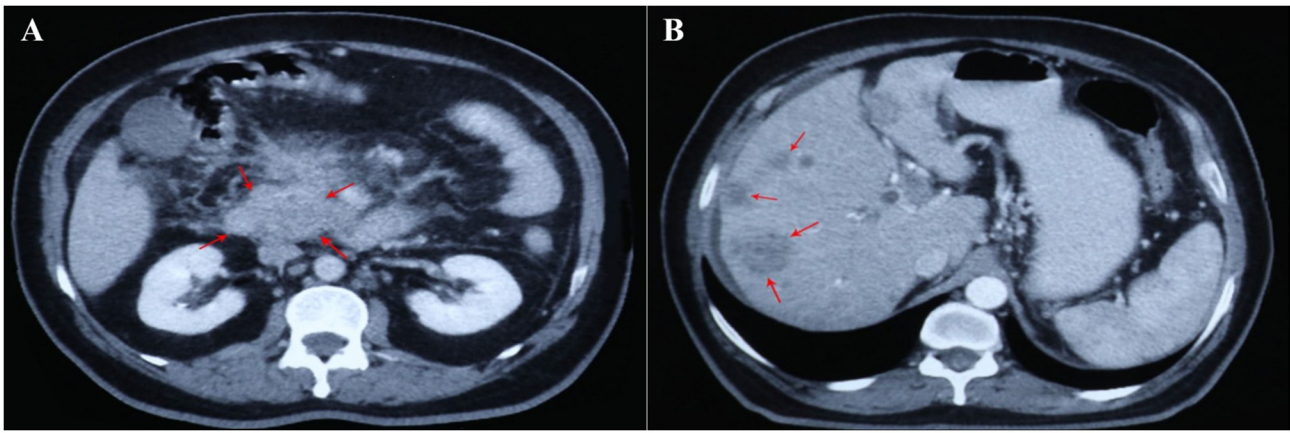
Pre-selpercatinib treatment contrast-enhanced computed tomography abdomen axial section (venous phase) showing (A) mildly heterogeneously enhancing primary mass lesion (red arrows) measuring ~3.8 (anteroposterior dimension) x 5.6 (transverse dimension) x 5.8 (craniocaudal dimension) cm in the head and uncinate process of the pancreas, and (B) multiple hypoenhancing hepatic metastases (red arrows), the largest measuring ~2.2x2.0 cm.
